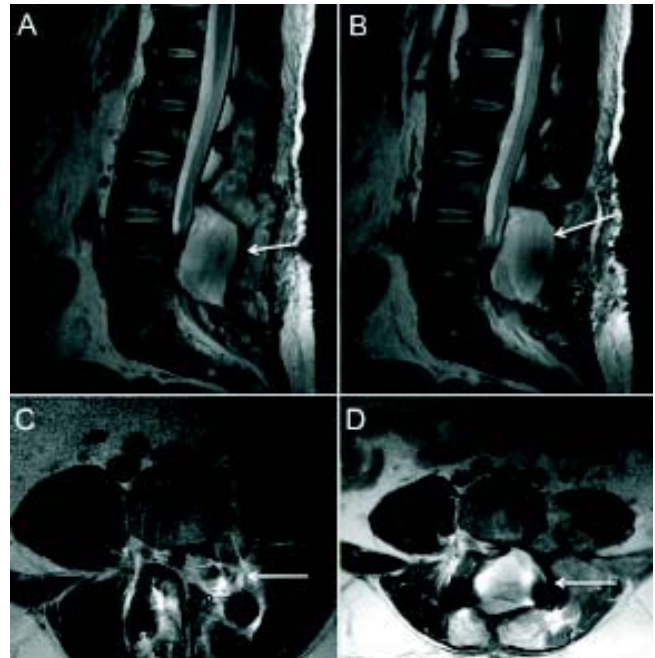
Postoperative lumbar spine MRI. A and B. Sagittal plane images showing evidence of the dural patch placed over the dural aperture there is epidural fluid collection causing compression of the *cauda equina* at the levels L4 and L5. C and D. Axial plane images depict the reflection artifacts associated to metallic rods in oblique position, rods contacted the boundaries of the epidural fluid collection, there was evidence of lumbar spinal canal stenosis.
